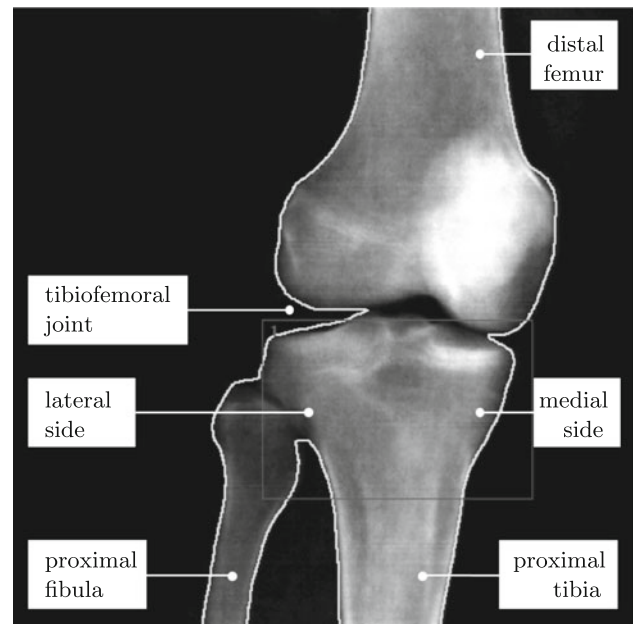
Characterization of density profile through Dual-Energy X-ray Absorptiometry, DEXA, of the study subject's right knee. A subject-specific geometric model of the proximal tibia is generated from the outline of the DEXA scan. The gray-scale coded bone mineral density measurement is used to validate our bone growth model
